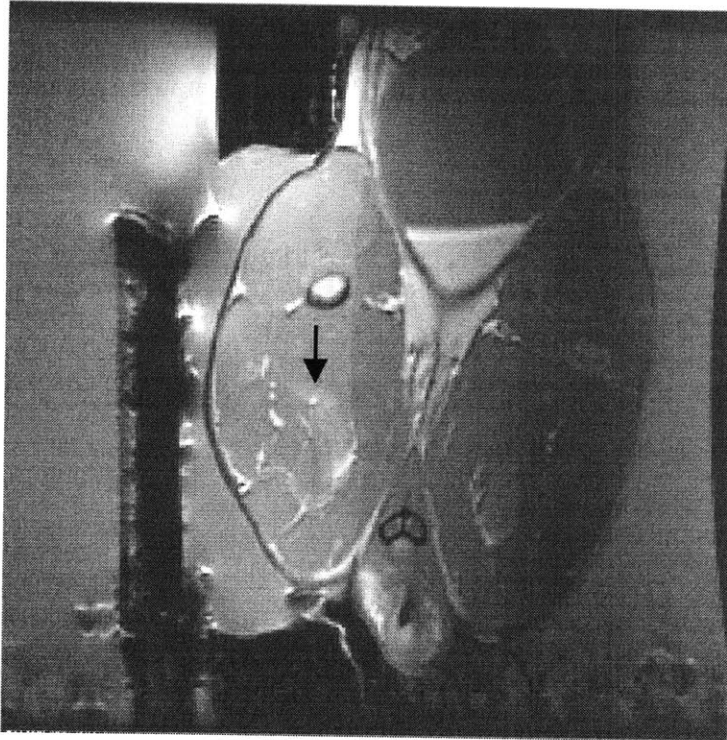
T2-weighted image after sonication and cooling. The arrow indicates the lesion created by sonication shown in Figure 4-6.
